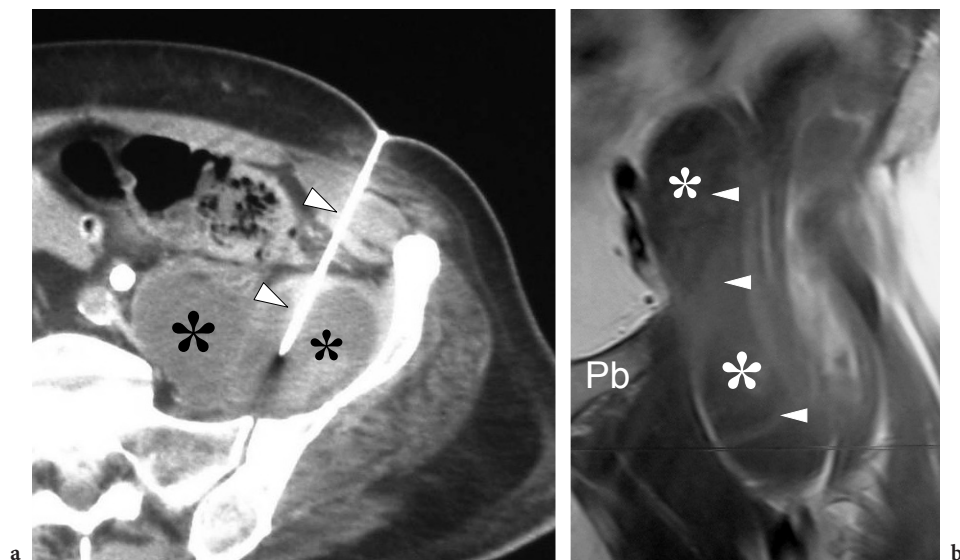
Extension of iliopsoas bursitis within the pelvis. a Axial CT scan demonstrates a large mass (*asterisks*) filled with hypodense fluid in the left pelvic fossa, close to the ilium. Observe the needle (*arrowheads*) guided within the mass for percutaneous biopsy. b Coronal Gd-enhanced T1-weighted MR image reveals an enlarged bursa located, in part, within the pelvic cavity (*asterisks*) and contrast material uptake by its walls and septa (*arrowheads*). *Pb*, pubis
